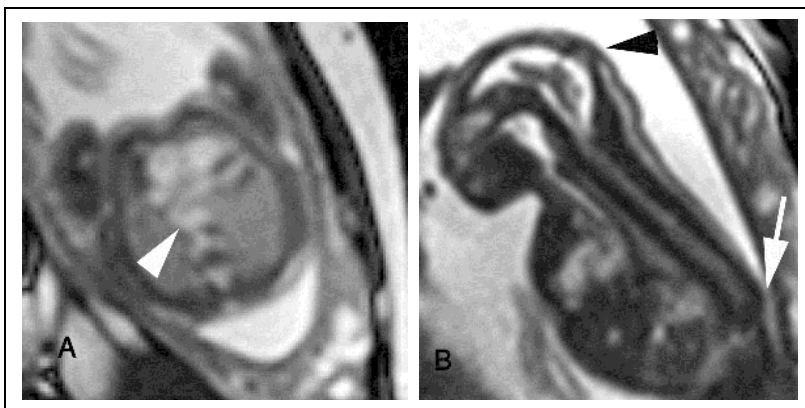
Fetal MRI of a cerebro-arthrodigital syndrome at 20 weeks' gestation. (A) Axial T2-SSFP of heart shows right sided aortic arch with aberrant left subclavian artery (arrowhead) in association with Fallot's tetralogy. Sagittal MRI of the fetal body of the same fetus shows associated microcephaly (arrowhead) and sacral agenesis (arrow).
